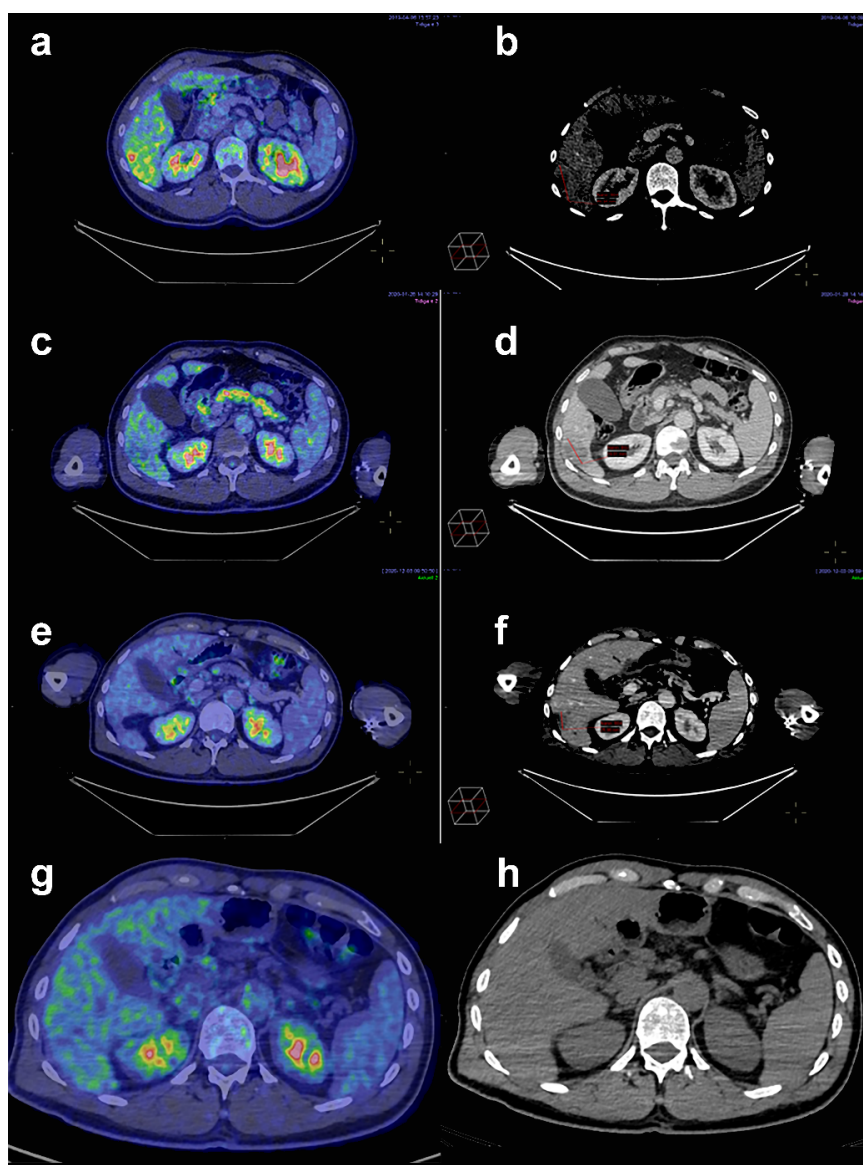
A 56-year old Caucasian man was diagnosed with metastatic uveal melanoma in April 2019. He underwent a baseline PET/CT scan at 6/4/2019 where a 50-mm according to RECIST 1.1 liver metastasis laterally dexter is visible both in the fusion image (1a) with a SUV max uptake at 5,9 and in CT image (1b). Treatment with NIVO3+IPI1 was initiated in May 2019. He received four such cycles followed by single nivolumab 480 mg every 4 weeks that was initiated in September, 2019. As shown in 1c there was no uptake in the fusion image (complete metabolic response CMR) in January 2020. The size of the metastasis in 1d was 40 mm. Since April 2020 due to the COVID-19 pandemic the patient received pembrolizumab 400 mg every six weeks instead of nivolumab. The treatment was paused in September 2020. In December 2020, ongoing CMR as shown in 1e, while the size of the metastasis was only 26 mm in 1f. At the latest PET/CT scan, in February 2021, was observed no evidence of metastatic disease nor in fusion images (1g) nor in CT images (1h).
